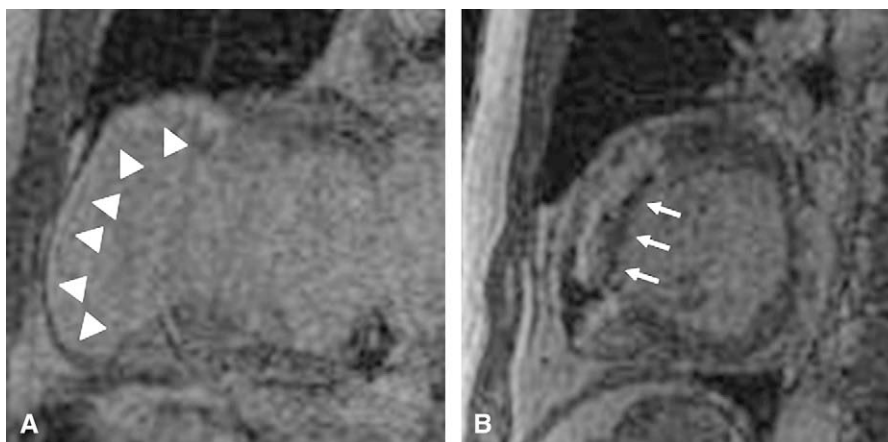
Preoperative and postoperative long-axis delayed-enhancement magnetic resonance images in patient with anteroapical dyskinetic aneurysm. Preoperative image shows transmural hyperenhancement area at anteroapical wall (A, arrowheads). After operation, hyperenhancement area was completely excluded with endoventricular patch (B, arrows).
